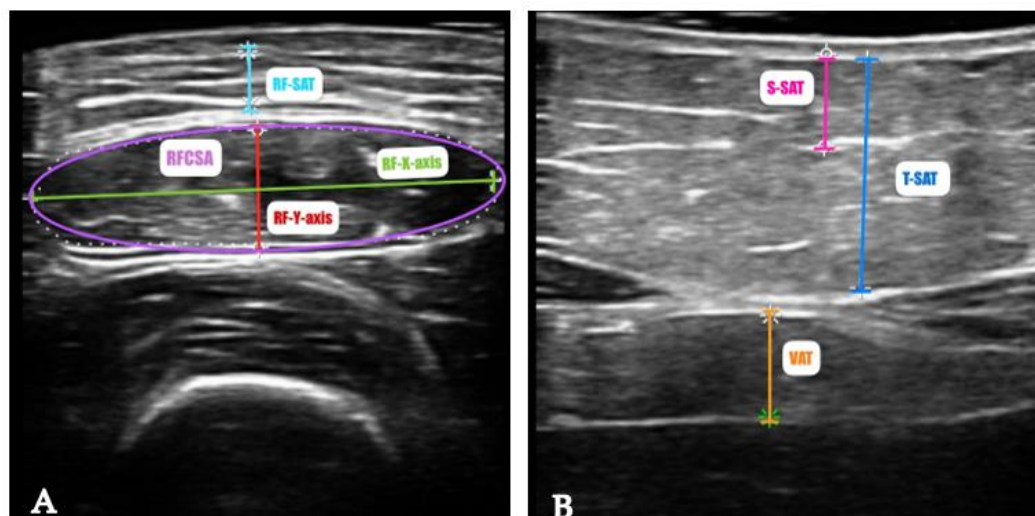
Measurement of rectus femoris (A) and abdominal adipose tissue (B) by ultrasound of a patient of our sample. Abbreviations - RFCSA: rectus femoris cross sectional area; RF-Y-axis: rectus femoris Y axis or muscle thickness; RF-X-axis: rectus femoris X axis; RF-SAT: rectus femoris superficial adipose tissue; VAT: visceral adipose tissue; T-SAT: total subcutaneous adipose tissue and S-SAT: superficial subcutaneous adipose tissue.
